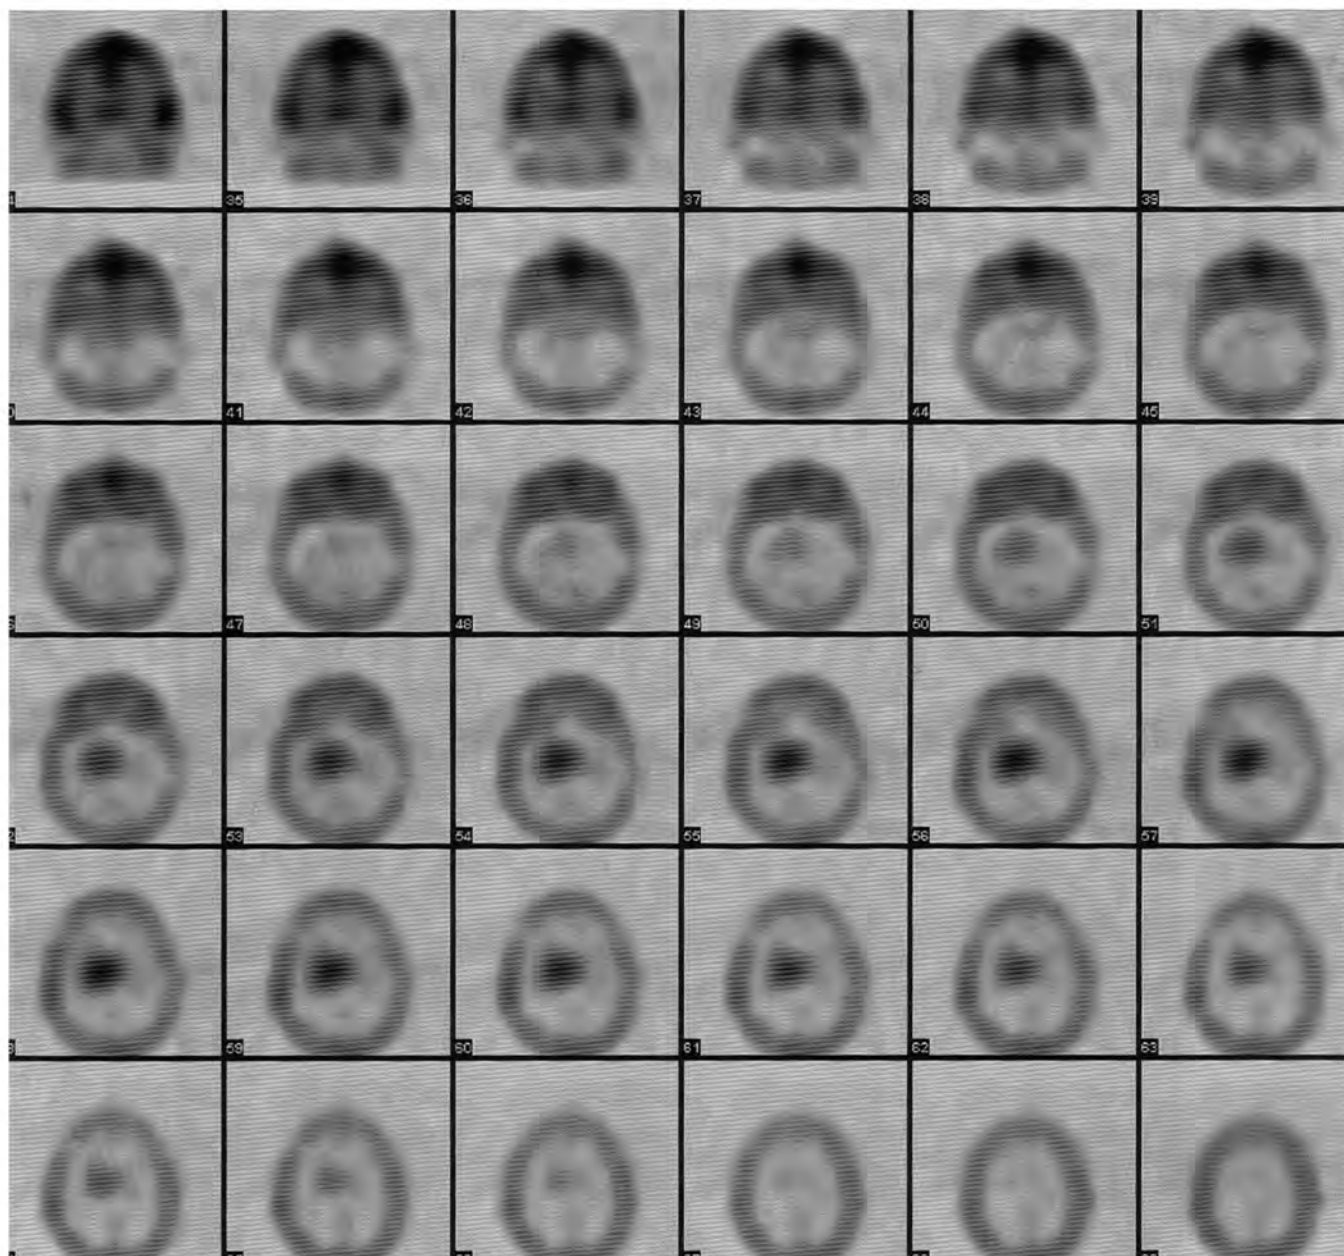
Thallium-201 SPECT images of the brain demonstrate scan intense tracer uptake corresponding to the right periventricular mass. The target to background (contralateral brain) ratio is 3.3. The findings are compatible with central nervous system (CNS) lymphoma in an immunocompromised patient.
